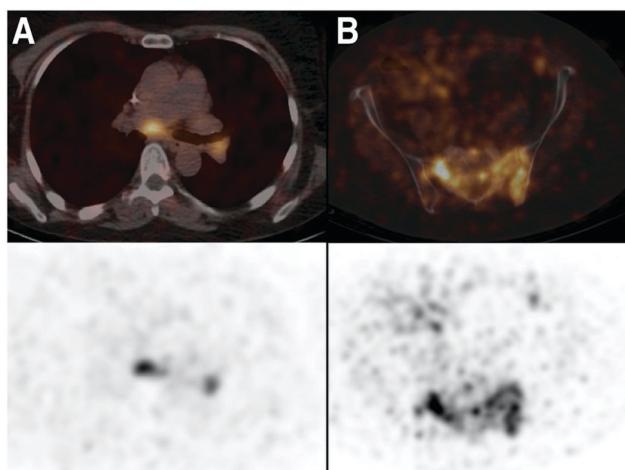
PET/CT images from the phase I clinical trial of ^{68}Ga -anti-HER2 Nanobody in breast cancer patients. (A) Patient 18, with invaded lymph nodes in the mediastinum and left hilar region. (B) Patient 20, with bone metastasis in the pelvis. PET/CT images (top) and PET images (bottom). Adapted from ref. 97.
